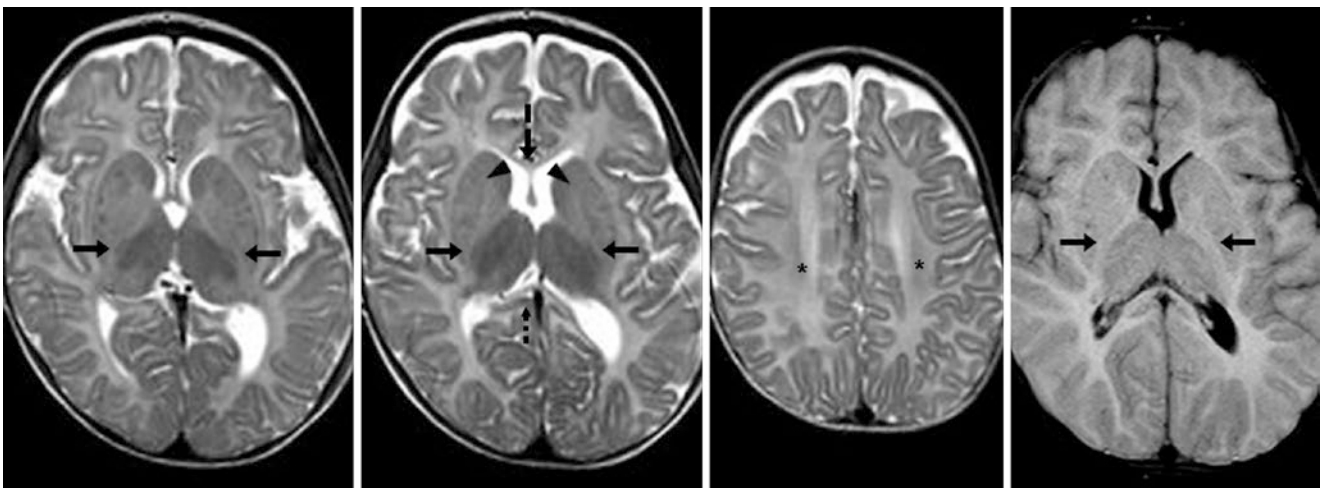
Comparison case of hypomyelination in GM1 gangliosidosis. A 5.5-month-old with weakness had a 1.5T MRI with SE T2WIs (*leftmost images*) and FLAIR (*right*). The ALICs (*arrowheads*), CS (*dotted arrow*), and CG (*dashed arrow*) were unmyelinated. The PLICs
